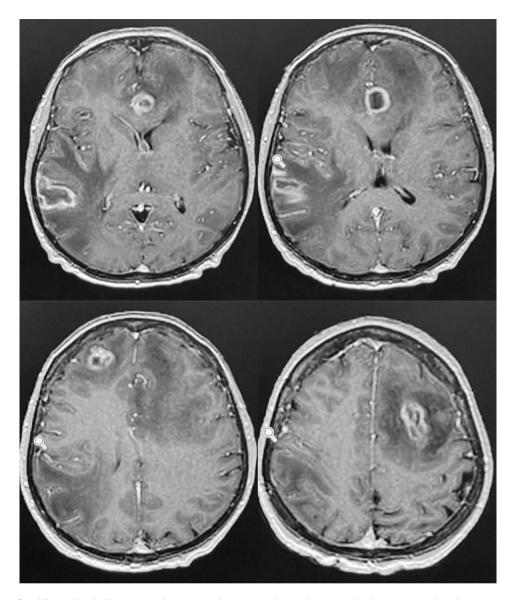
This series of axial T1-weighted MRI images with contrast enhancement shows a large, irregular, heterogeneously enhancing mass predominantly in the right frontal and temporoparietal regions. The mass involves the midline structures, causing significant vasogenic edema and a midline shift. In addition, a distinct enhancing lesion is noted in the left parietal lobe. The lesions demonstrate heterogeneous enhancement with areas of necrosis
